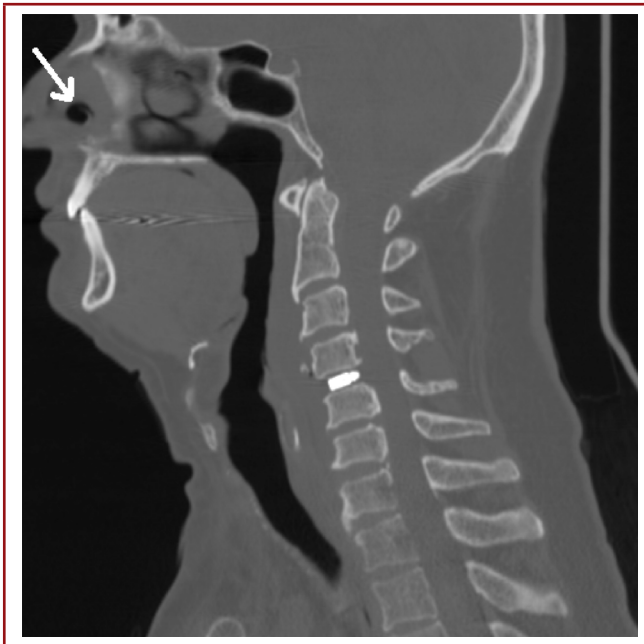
A postoperative sagittal CT scan shows a PEEK cage and postoperative decrease in edema and compression. Patient had approximately 6mm septal perforation (arrow).
